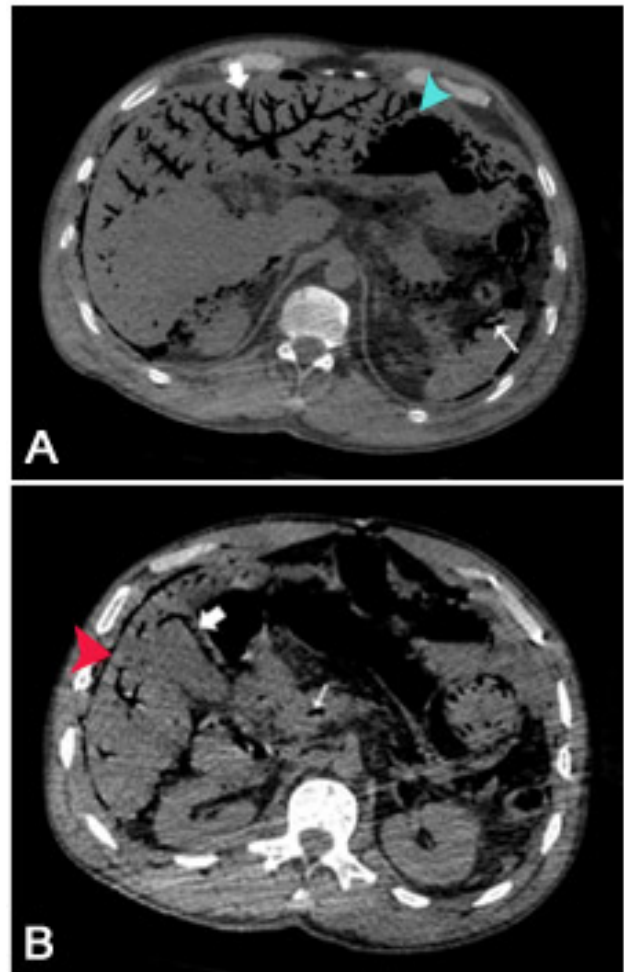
A. Computed tomography of the abdomen in axial section. Shows a collection of air in the periphery of the liver corresponding to pneumoperitoneum (red arrow). The gallbladder is observed with air bubbles in the wall (thick white arrow) and the splenoportal venous junction shows gas inside (thin white arrow). You can see the small bowel loops distended with scarce collections of air in your wall. B. Computed tomography image in axial section. The branched form of intrahepatic portal venous gas (thick white arrow) is observed. The thin arrow indicates the gas at the level of the splenic and intrasplenic vein. There are also small gas bubbles in the wall of the stomach (blue arrow).
